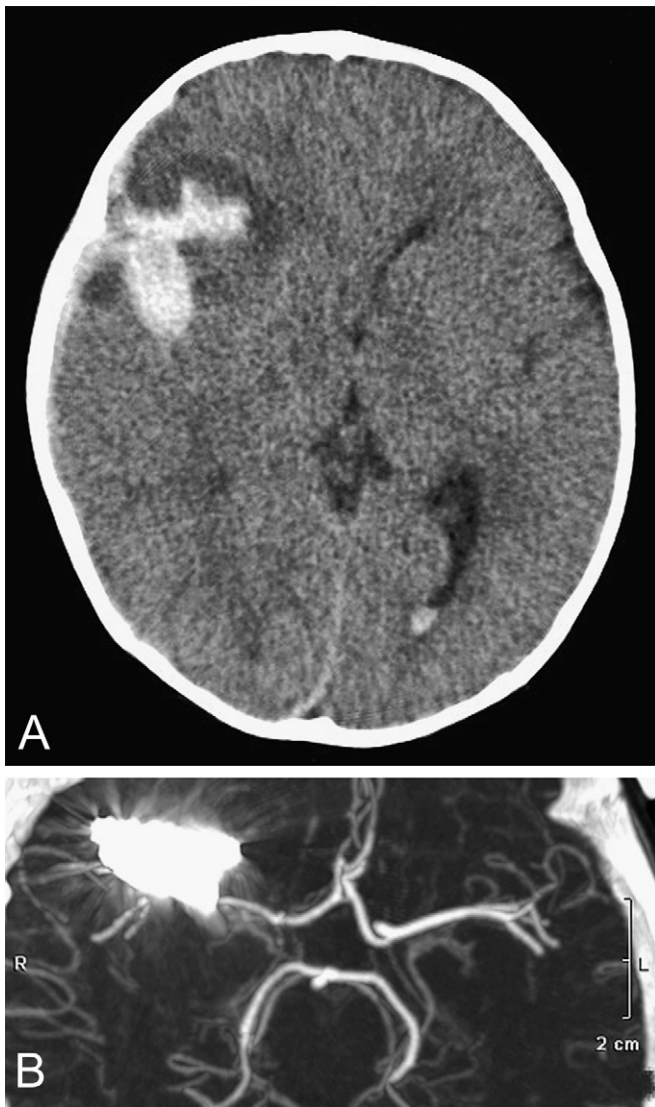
Preoperative noncontrast axial CT brain and CT angiogram of the circle of Willis. A, Acute subarachnoid hemorrhage centered on the right Sylvian fissure with probable areas of infarction in the posterior right frontal lobe. There is mass effect and midline shift to the left by 4 mm and effacement of the right lateral ventricle; a small amount of acute blood is visible in the posterior horn of the left lateral ventricle. B, Reconstruction: a large complex aneurysm arising from the anterior branch of the right middle cerebral artery distal to the bifurcation of the M1 segment.
